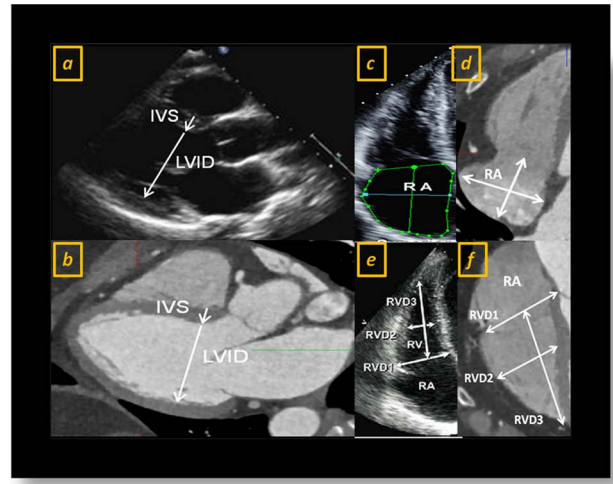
CCTA cardiac dimension reference ranges utilizing ASE recommended techniques in (a, b) parasternal long axis images for left ventricular dimensions, (c, d) apical 4-chamber view for atrial area measurement at end-systole, as well as (e, f) right ventricular dimensions at end-diastole as generated by Merge Cardio™ CVPACS (Merge Healthcare, Chicago, IL, USA) for TTE images and Vitrea® Workstation (Vital Images, Inc., Minnetonka, MN, USA) for CCTA images.
